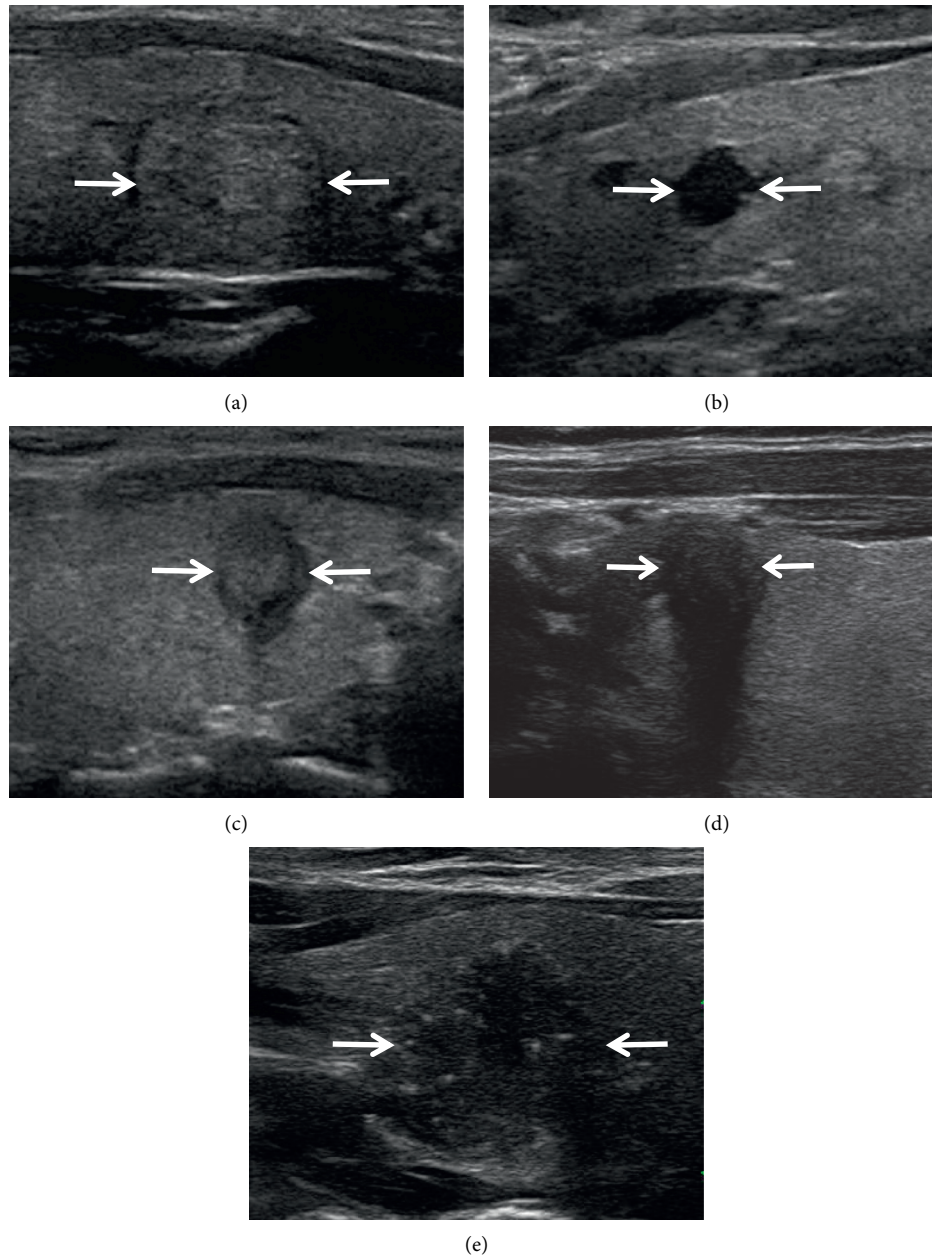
Thyroid Imaging Reporting and Data System: (a) category 3, no suspicious ultrasound characteristics; (b) category 4a, one suspicious ultrasound characteristic (marked hypoechoogenicity); (c) category 4b, two suspicious ultrasound characteristics (ill-defined margins and higher-than-wide); (d) category 4c, four suspicious ultrasound characteristics (solid components, marked hypoechoogenicity, ill-defined margins, and higher-than-wide); (e) category 5, five suspicious ultrasound characteristics.
